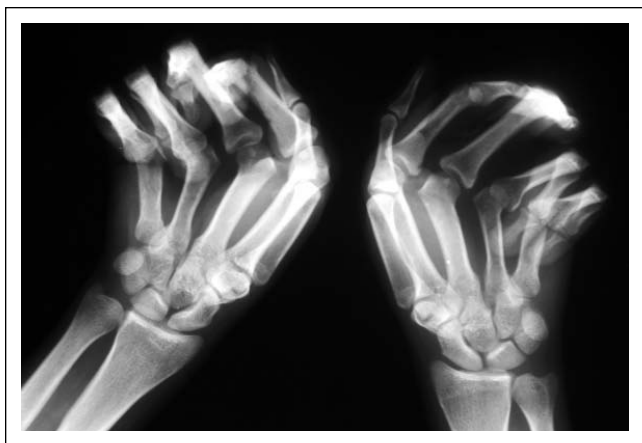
BM. Antero-posterior radiograph of the hands showing digital contractures.
